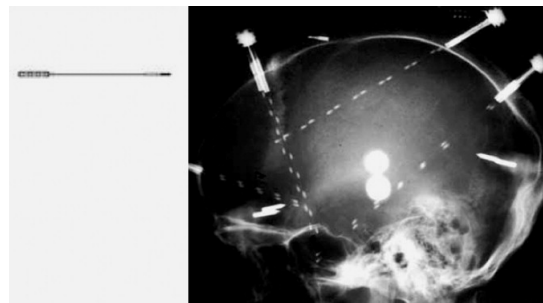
Left: StereoElectroEncefalographic electrode. Right: Post StereoElectroEncefalographic electrodes implanting radiography.*
